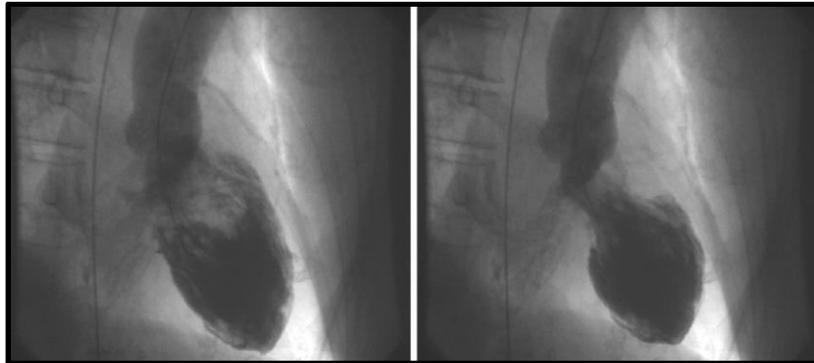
Typical appearance in diastole and systole of Takotsubo of the apical 2/3 "apical ballooning syndrome"
